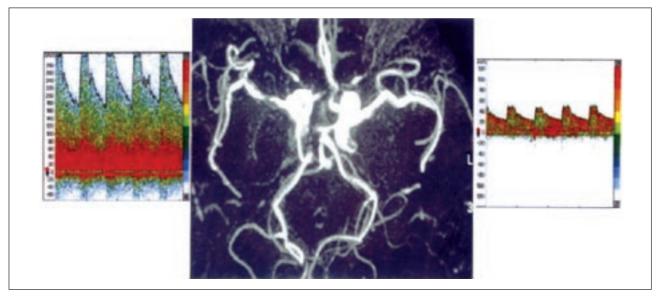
Magnetic resonance angiography and transcranial Doppler ultrasound images of right middle cerebral artery stenosis and normal left middle cerebral artery
